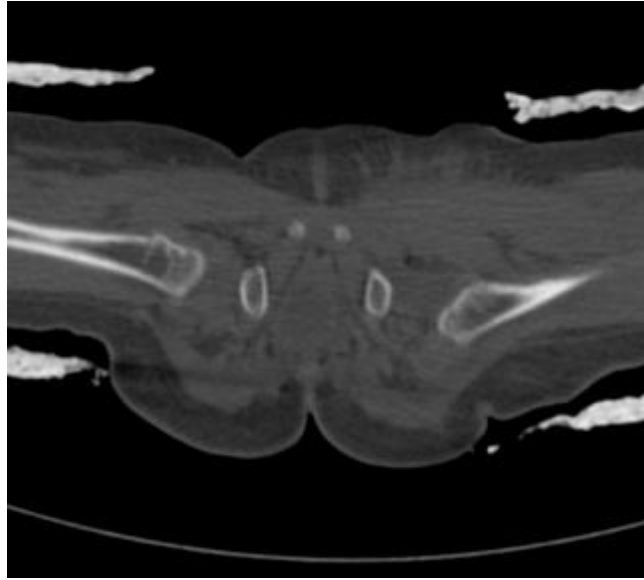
Image of a CT scan slice
